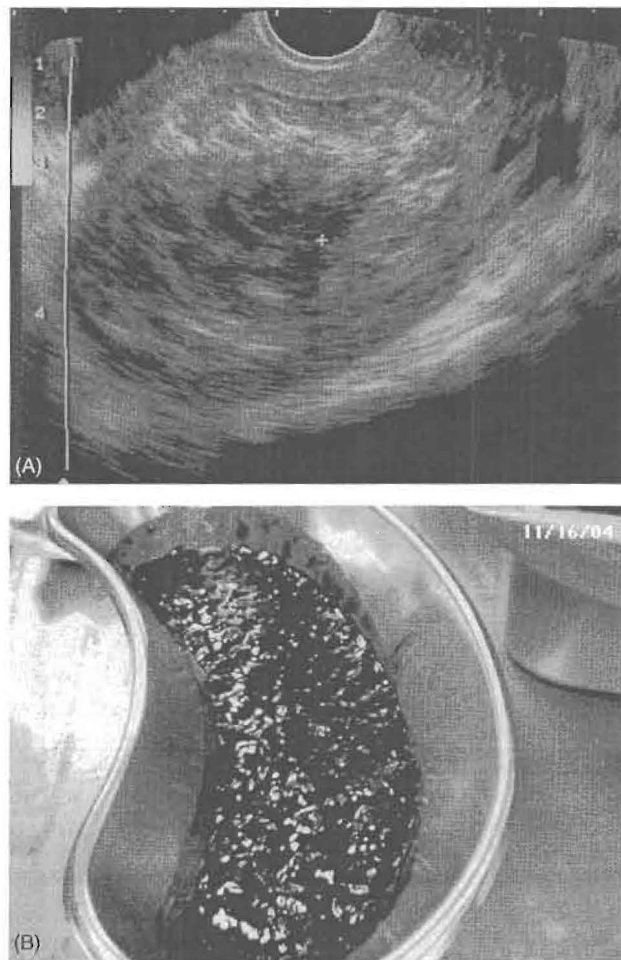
(A) Transvaginal ultrasound image showing intracavitary heterogeneous echoes in a patient with hematometra diagnosed 4 days after aspiration abortion at 12 weeks' gestation. (B) Uterine reaspiration yielded approximately 150 cc of blood clots and serum only.
